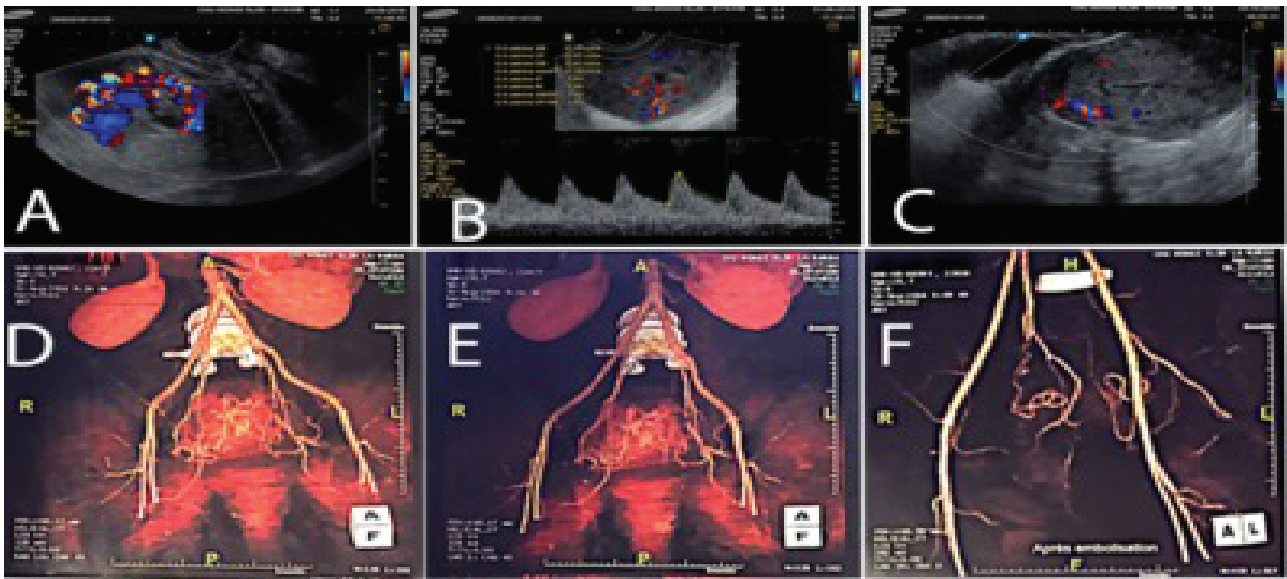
1A: 2D transvaginal ultrasonography shows intrauterine heterogeneous image in relation with a retained product of conception, an irregular hypoechoogenic area within the myometrium with high velocity and a bidirectional blood flow in color Doppler.
